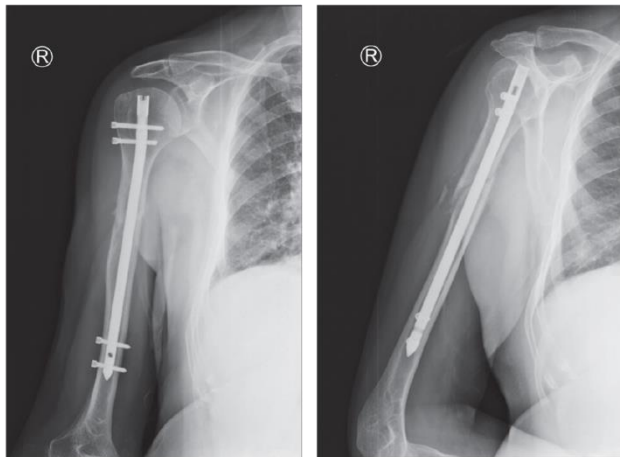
X-ray images of patient M., front and lateral views. Osteosynthesis of the right humerus with a locking screw. The position of the fragments and the implant is satisfactory
